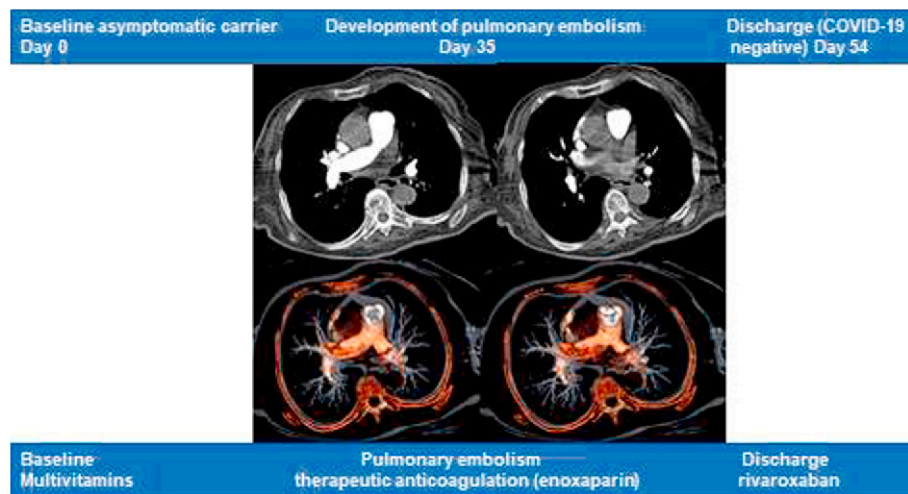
Clinical course of our asymptomatic COVID-19 patient (case 2) from baseline to the development of pulmonary embolism as depicted by contrast chest computed tomography, which revealed multiple filling defects of segmental and lower lobular branches of the right pulmonary artery. Finally the patient was discharged on rivaroxaban therapy.
